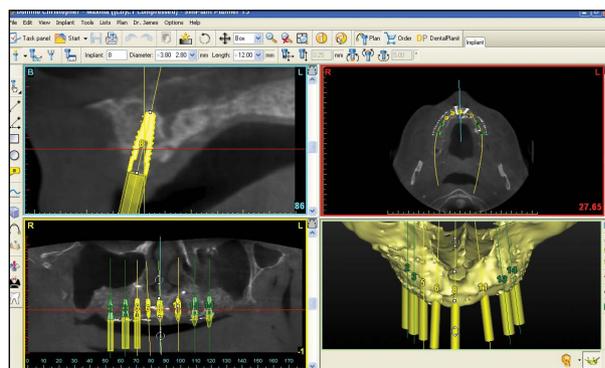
CBCT post sinus and block graft for implant planning.
